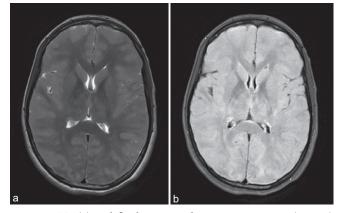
T2 (a) and fluid-attenuated inversion recovery (FLAIR) (b) axial magnetic resonance imaging images of the patient showing diffuse cerebral edema.
